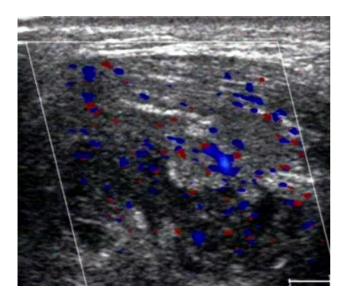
Color Doppler imaging of the right posterior thigh shows an ill-defined heteroechoic lesion with perifocal hypervascularity.
